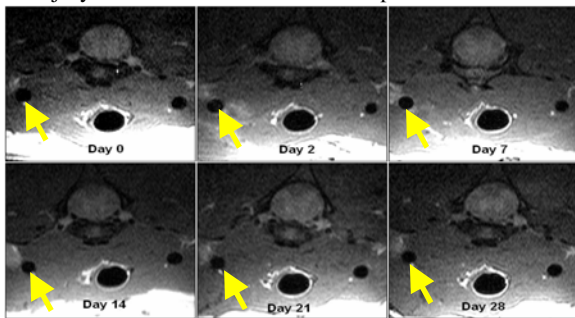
Typical MR images. (LCCAs indicated by arrows)
